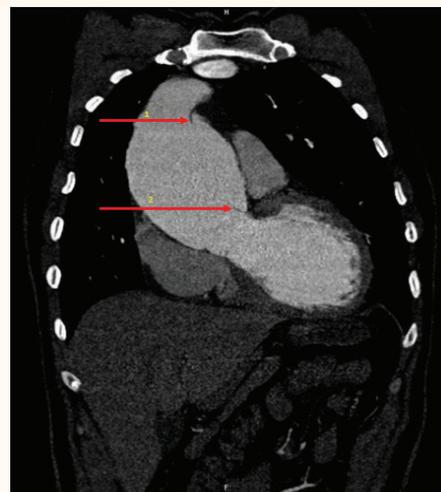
Coronal reformat of the same computed tomography (CT) chest scan showing the extent of the aneurysmal dilatation of the ascending aorta as well as the dissection (both arrows).
